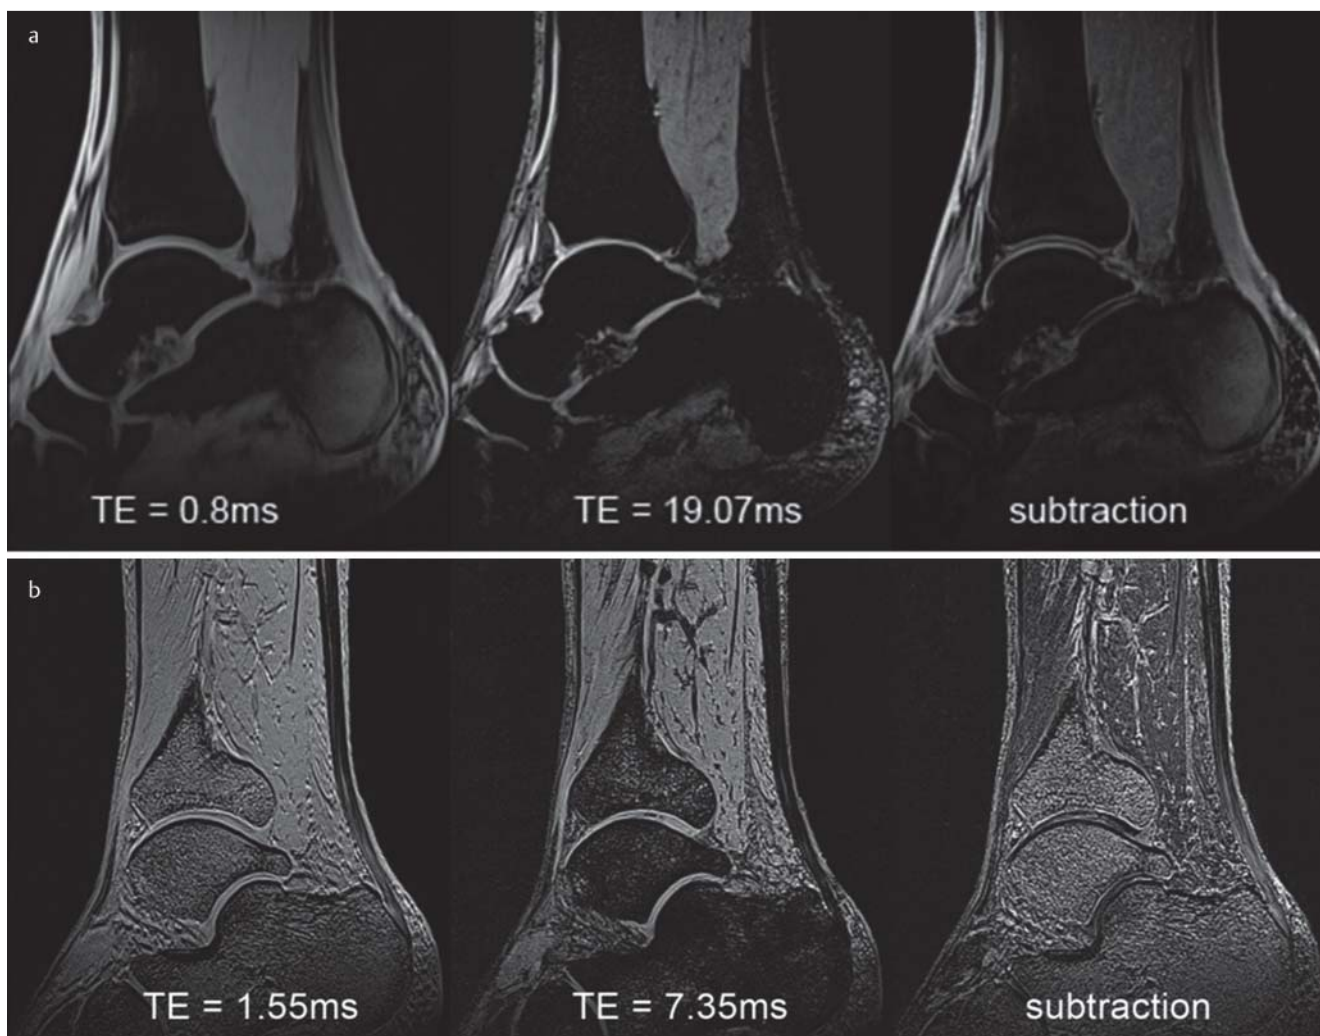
shows sagittal MR images of an Achilles insertional tendinopathy in a 39-year-old patient at 3 T a and 7 T b. Images with different echo times and a corresponding subtraction image are presented (courtesy of Prof. Trattning and co-workers, Vienna, Austria).
